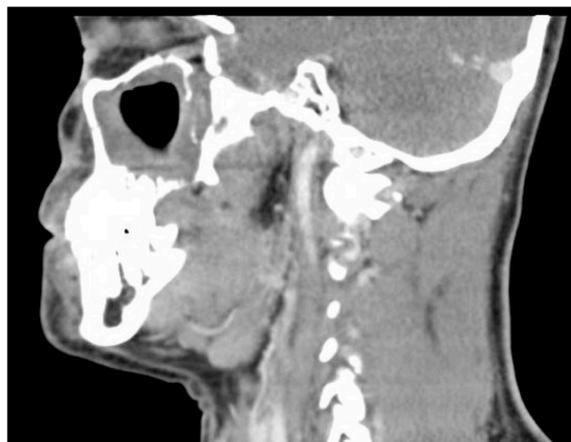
A 1-week post-treatment CT neck with contrast soft tissue window, sagittal cut, showed interval decrease in size of soft tissue mass in left maxillary sinus and masticator space.
